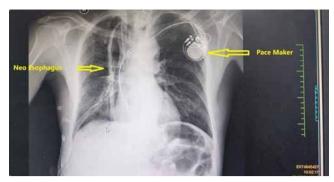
Chest Xray with PPM, neoEsophagus
